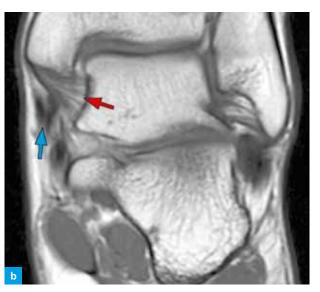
Normal anatomy of the deltoid ligament on MR-imaging. (a) T1-weighted coronal MR image shows the deep anterior tibiotalar ligament (red arrow), superficial tibiospring ligament (blue arrow), and flexor retinaculum (yellow arrow) at the level of the anterior colliculus of the medial malleolus. The tibialis posterior muscle tendon (PTT) is seen (green arrow) between the flexor retinaculum and the superficial deltoid ligament. (b) Intermediate-weighted coronal MR image at the posterior colliculus of the medial malleolus demonstrates the typical conical shape and striated appearance of the deep posterior tibiotalar ligament (red arrow) in close proximity to the PTT.
